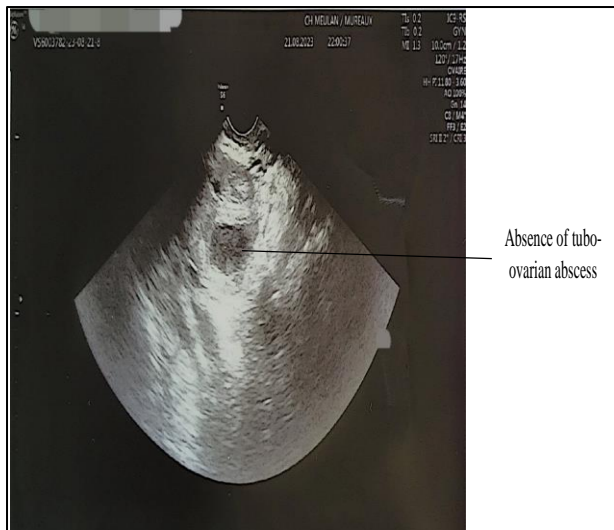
Ultrasound control after drainage of the tubo-ovarian abscess.
